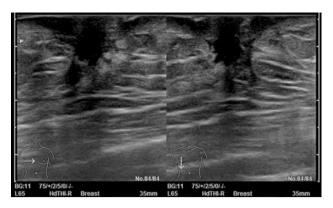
Ultrasonography shows a low echoic mass in the right retroareolar space
